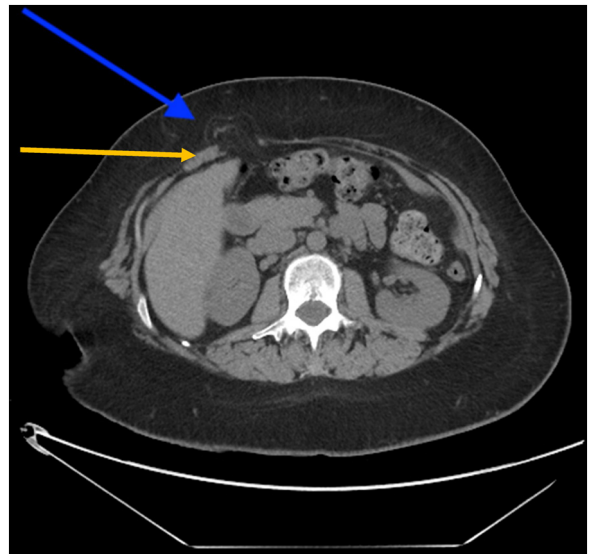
CT scan axial view of the right upper quadrant incisional hernia (blue arrow) through the right Rectus abdominis muscle (orange arrow).
